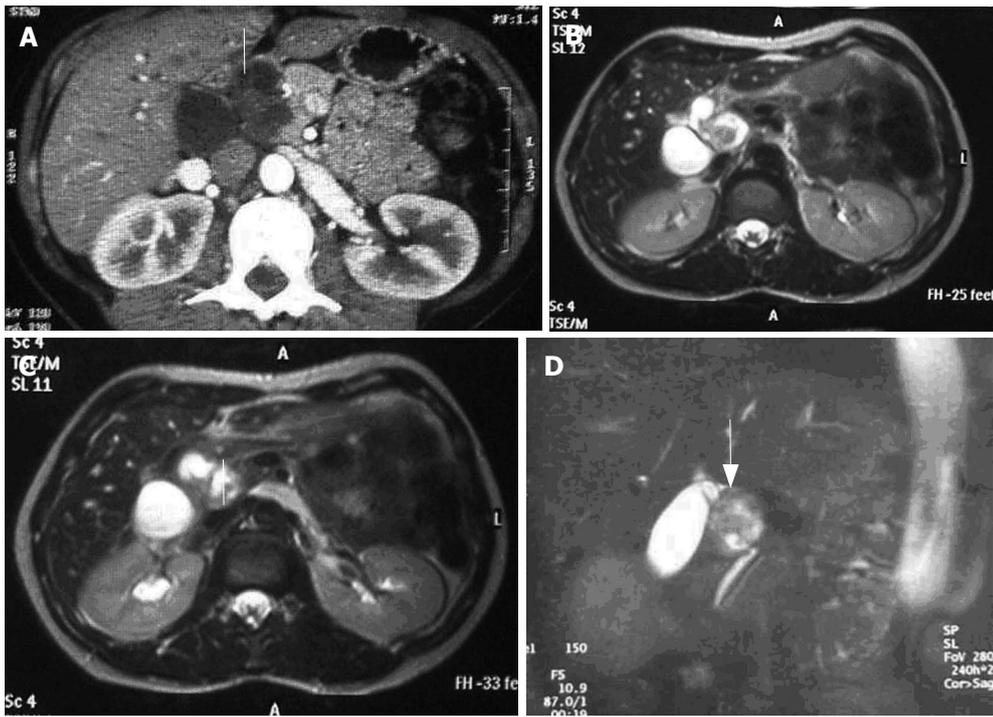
A: CT scan showing a very heterogeneous formation with a liquid content in close contiguity to the CBD (white arrow); B, C, D: Cholangio-MRI reveals a solid formation with a hypointense signal in the weighted T1 sequences at the pancreatic isthmus (white arrows) with dilation of the upstream bile ducts.
